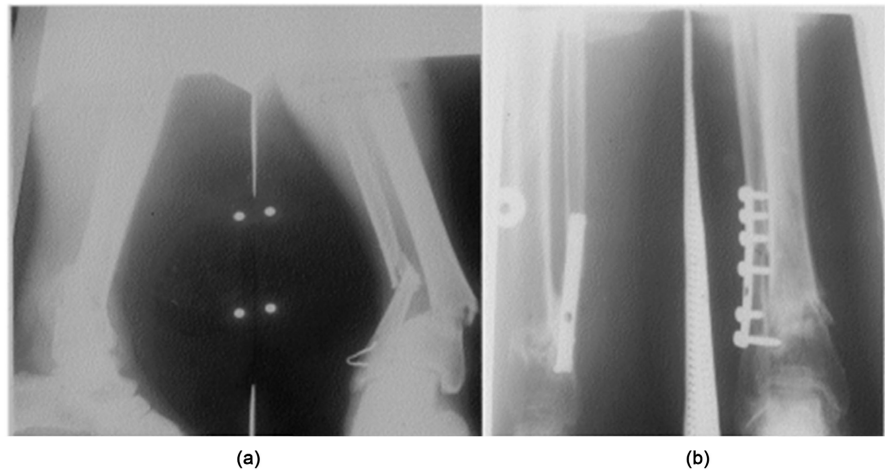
Osteosynthesis of the fibula transforms the fracture of two leg bones into a fracture of leg bones with intact fibula. (a) Preoperative X-ray profile and face; (b) Postoperative X-ray profile and face [12].
